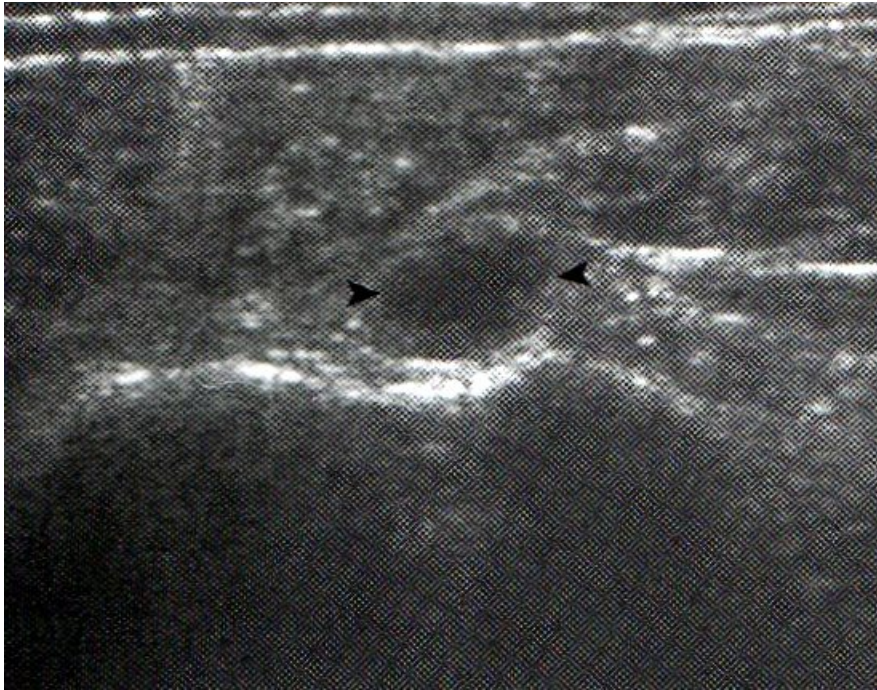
Joint effusion: biceps tendon sheath communication. Ultrasound image transverse over the distal bicipital groove shows anechoic joint fluid (*arrowheads*), which
